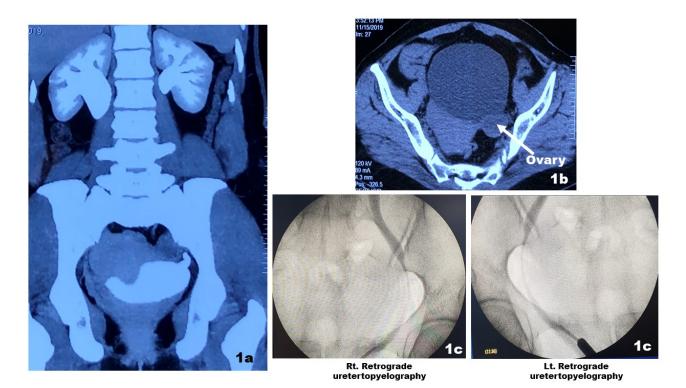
a: Contrast CT showing bilateral hydronephrouretrosis with thickened bladder wall; b: CT scan showing left ovary with cystic appearance; c: Retrograde uretertopyelography showing dilated upper ureter and narrow lower ureters
